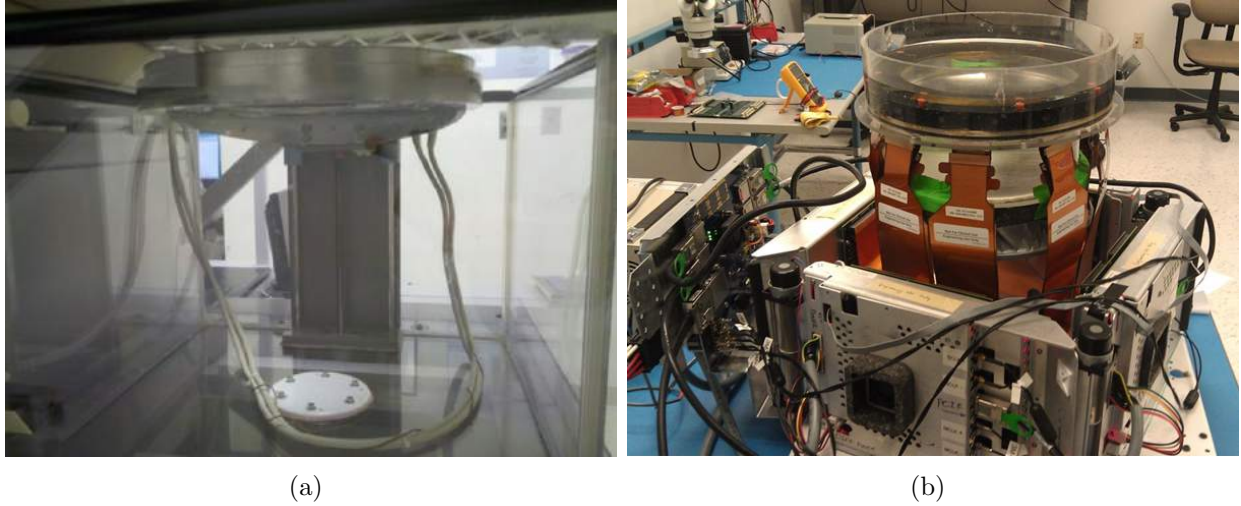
Ultrasound Tomography Device Transducer Rings. (a) CURE. (b) SoftVue.
